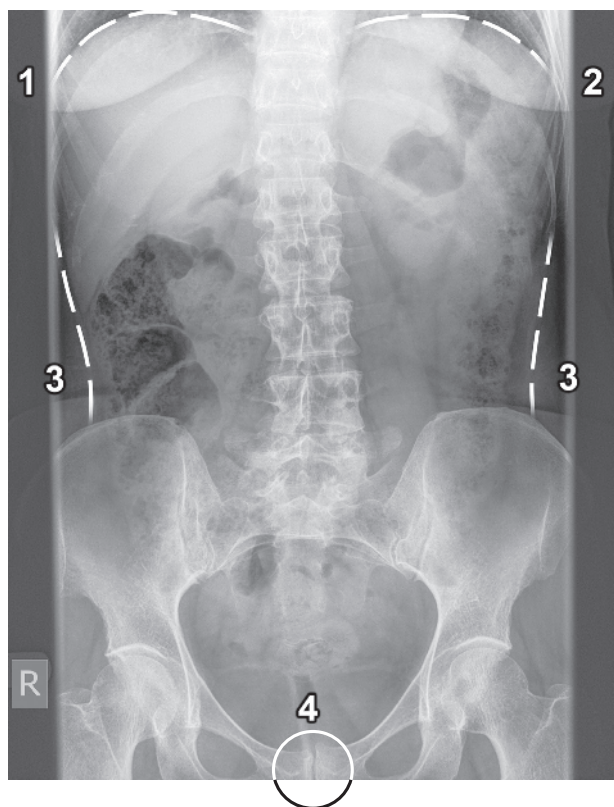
A normal abdominal radiograph showing the superior aspect of the liver (1), superior aspect of the spleen (2) and lateral abdominal walls (3) marked with dashed white lines. The pubic symphysis (4) is marked with a white circle (although ideally I would also like to see the inferior aspect of the pubic symphysis).
